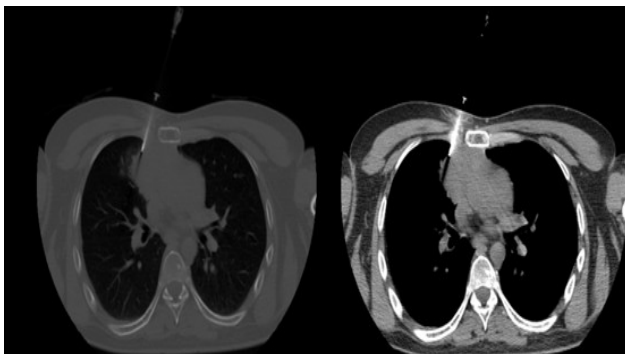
A CT-guided biopsy sample of a 45-year-old male patient's anterior mediastinal mass is shown. (arrow) The pathological diagnosis was Hodgkin Lymphoma.
